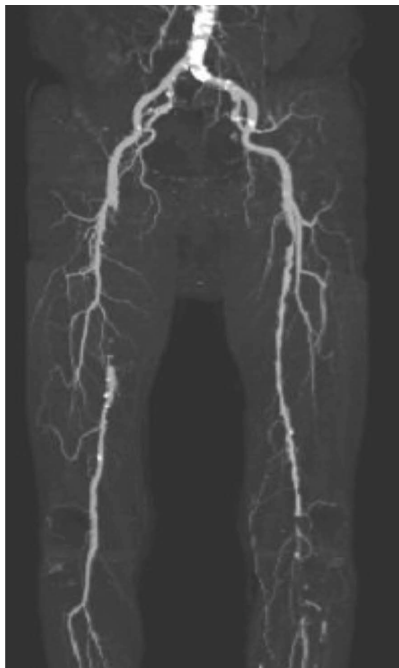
Computed tomography (CT) angiography of bi-lateral lower limb arteries.
